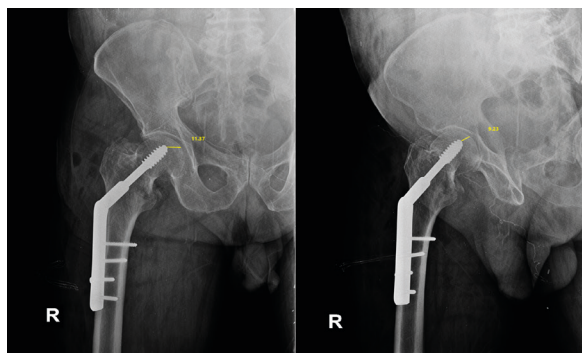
AP and lateral radiographs of the right hip in the immediate post-operative period, showing good fracture reduction and a well-positioned DHS implant, respecting the TAD (Tip Apex Distance) <25mm (Baumgartner index, represented by the measurement and numbers in yellow).
